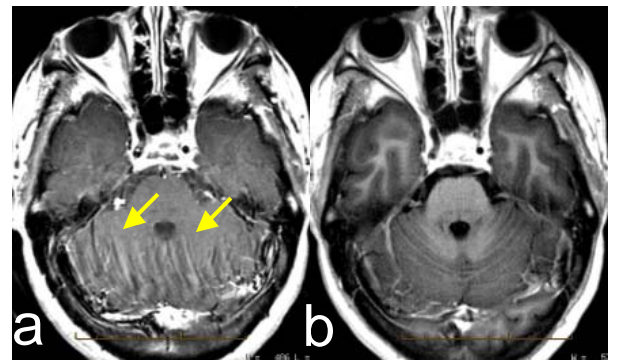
Post-contrast images acquired with (a) T1 SE and (b) T1 FLAIR PROPELLER.
